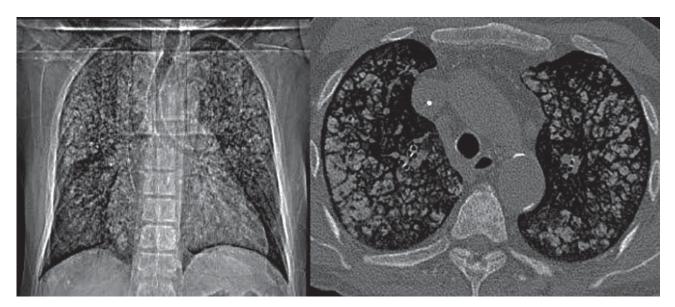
Lung destruction due to MPC in the chest-CT scan presented by Beyzaei et al. [12]
